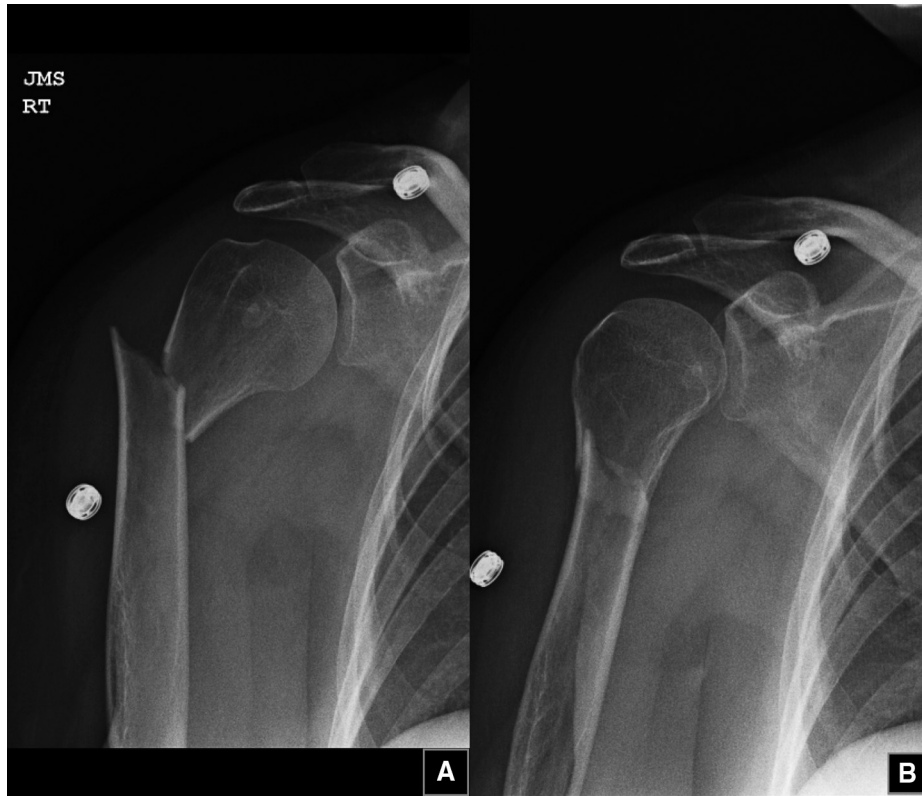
Anteroposterior radiographs in (A) external rotation and (B) internal rotation views on the date of injury (August 4, 2012).
